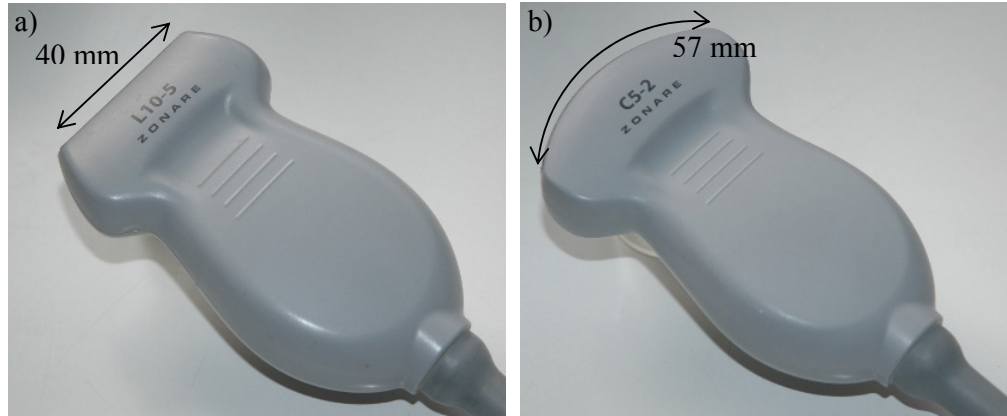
Photographs of the L10-5 (a) and C5-2 (b) diagnostic ultrasound probes that were used for active cavitation detection in this study.
